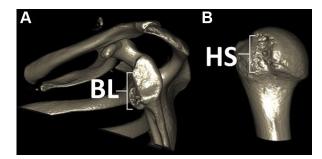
Preoperative 3D CT reconstruction images. (A) Lateral view of a 3D CT reconstruction of the left scapula, showing a bony Bankart lesion (BL) of the glenoid. (B) Posterior view of a 3D CT reconstruction of the proximal left humerus, showing a Hill–Sachs lesion (HS) on the posterolateral region of the humeral head. (3D, 3-dimensional; CT, computed tomography.)
